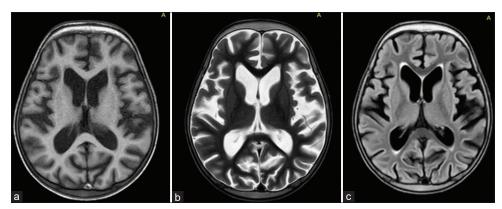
Predominant white matter loss. Axial T1W, T2W, and FLAIR images demonstrate diffuse mild dilatation of supratentorial CSF sulcal spaces and ventricular systems associated with mild diffuse white matter volume loss s/o cerebral atrophypredominantly white matter
